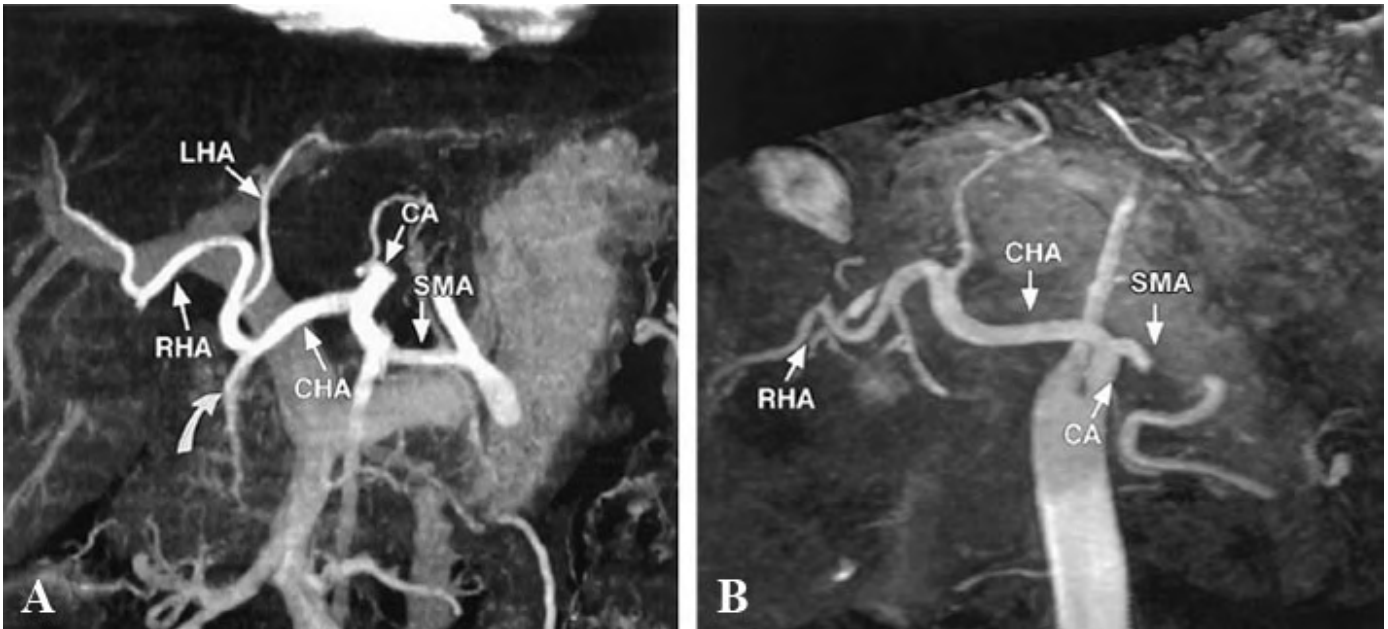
Reformatted images from CT (A) and MR imaging (B) data depict the normal course and branching pattern of the hepatic artery. Note that in a, the gastroduodenal artery (curved arrow) branches off from the common hepatic artery (CHA). The proper hepatic artery divides into the left hepatic artery (LHA) and right hepatic artery (RHA). CA celiac artery, SMA superior mesenteric artery.
